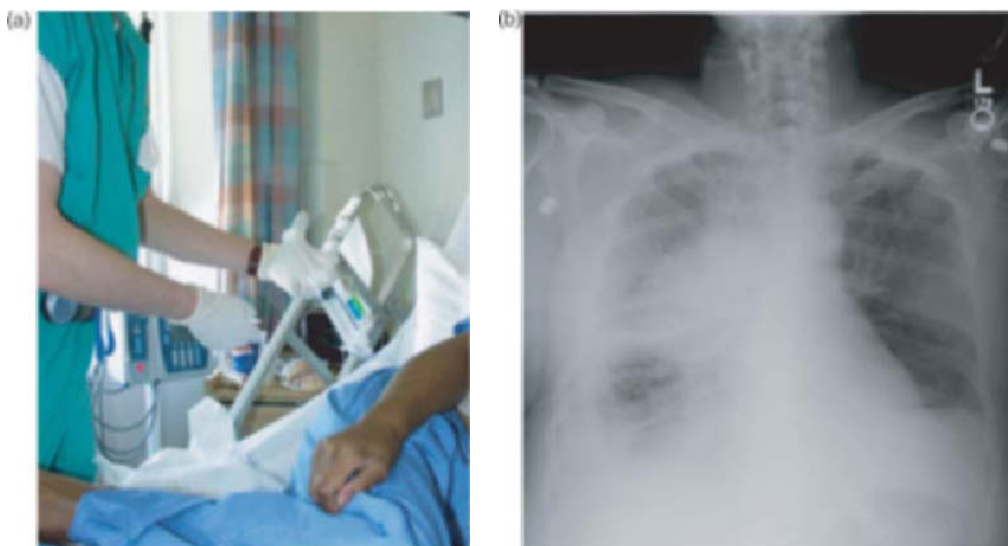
Small chest tube mediated chemical pleurodesis. (a) Technique of bleomycin infusion via right pleural catheter in 59-year-old female with refractory malignant pleural effusion secondary to metastatic breast carcinoma with large right mid-lung field mass. (b) Posteroanterior chest radiograph status post successful bleomycin pleurodesis with small thoracostomy tube visible at right base.
